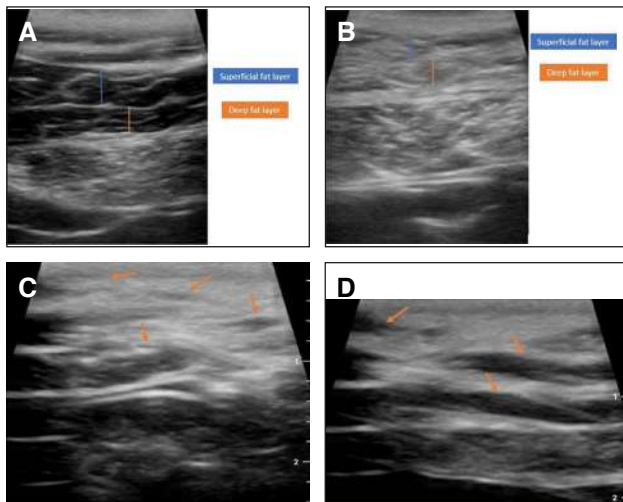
Ultrasound image of a 43-year-old female patient with 2 previous liposuctions. Images before surgery and upon completion in the abdominal area. (A) Irregularities in superficial and deep fat layers pretreatment. (B) Homogenization and regularization across distinct layers of adipose tissue posttreatment. (C) Soft nodules in superficial and deep fat layer pretreatment. (D) Hard nodules in superficial and deep layer pretreatment.
